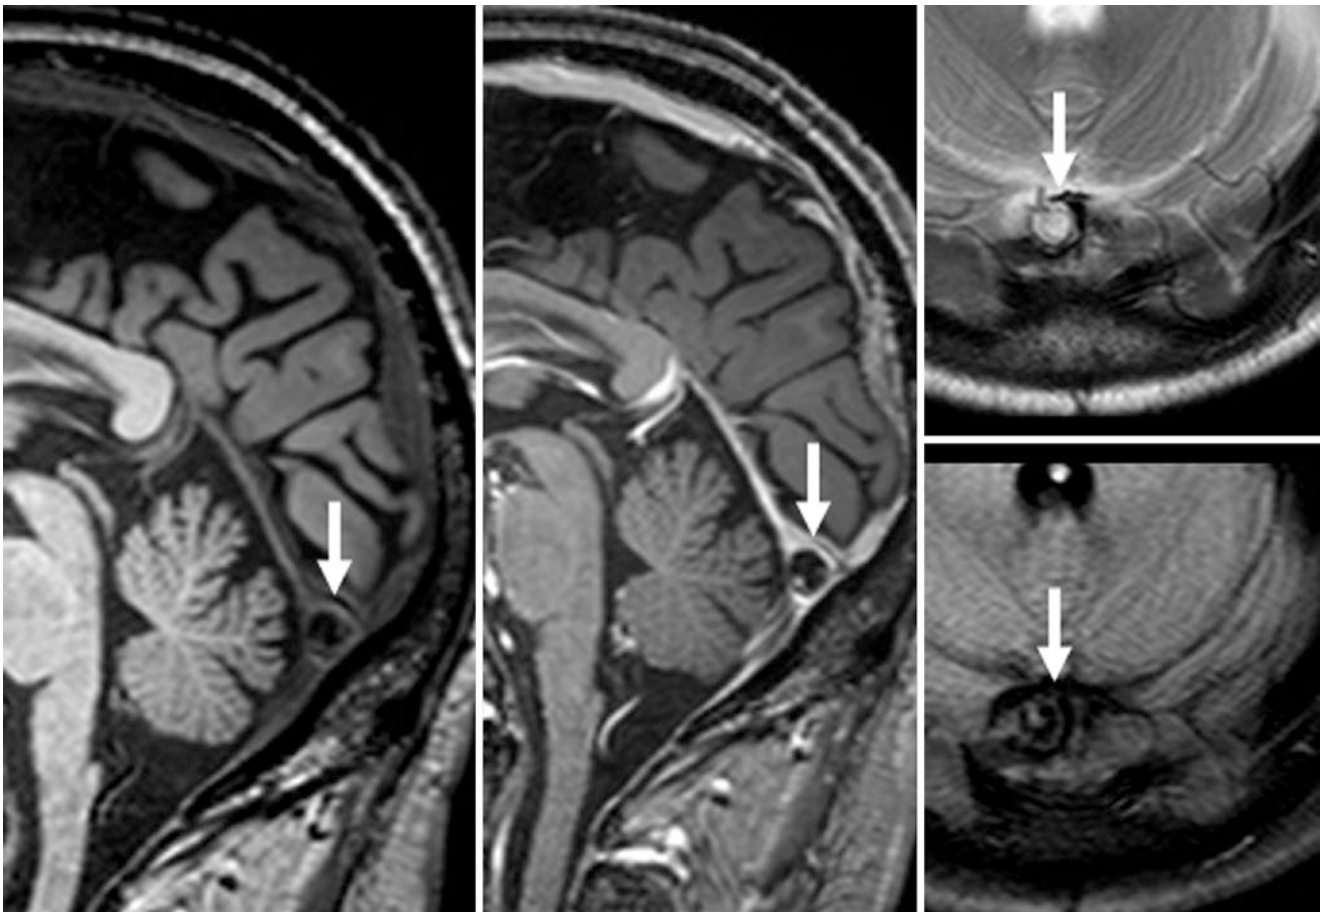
52-year-old with an arachnoid granulation (*arrows*) of the torcular on sagittal precontrast (*left*) and postcontrast (*middle*) T1WI MRI. Note the bright signal intensity on axial T2WI (*top right*) and the suppression similar to CSF on axial FLAIR (*bottom right*)
